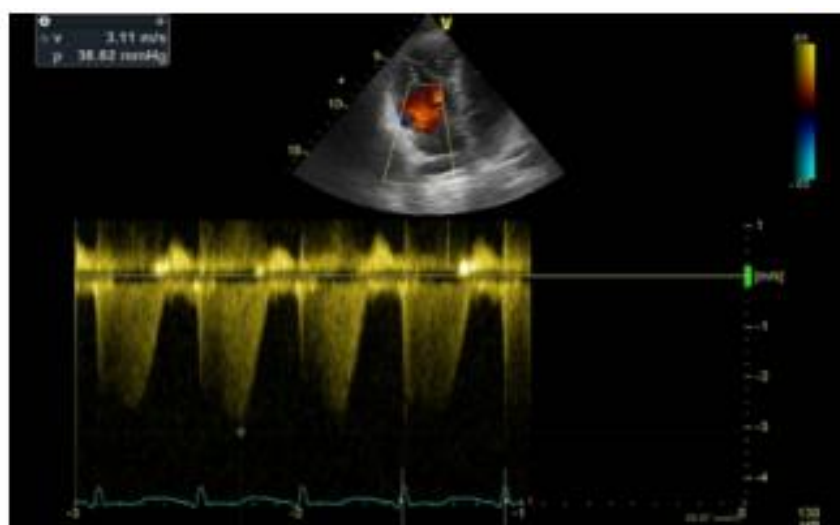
Transthoracic cardiac ultrasound post fibrinolysis, systolic pressure in the pulmonary artery- 38 mmHg
